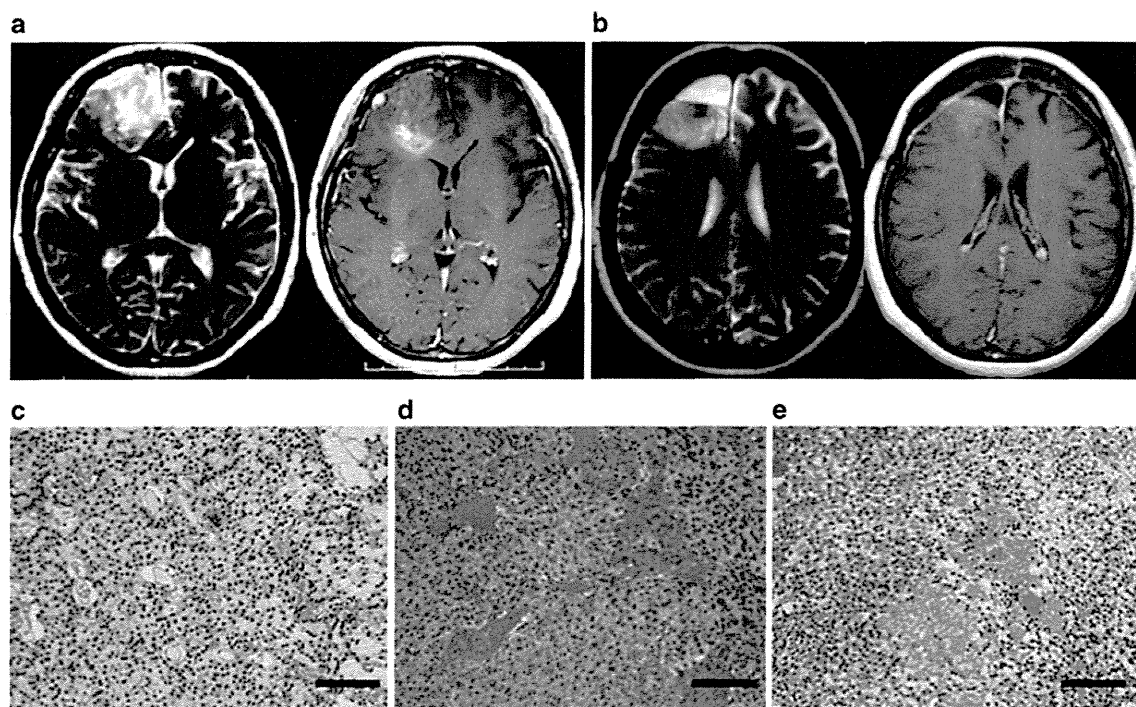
Representative case with malignant transformation in a 41-year-old woman with right oligodendroglioma in the right frontal lobe. T2-weighted (*left*) and T1-weighted with gadolinium (*right*) magnetic resonance (MR) images at first presentation (a), demonstrating that the tumor had a distinct border and slight enhancement. Primary tumor tissues obtained from resection of the tumor consisted of round to oval neoplastic cells with a perinuclear halo but without microvascular proliferation or necrosis, and the diagnosis was oligodendroglioma (c). Analysis for IDH1 mutation revealed the tumor had the IDH1 R132H mutation. She did not receive any
